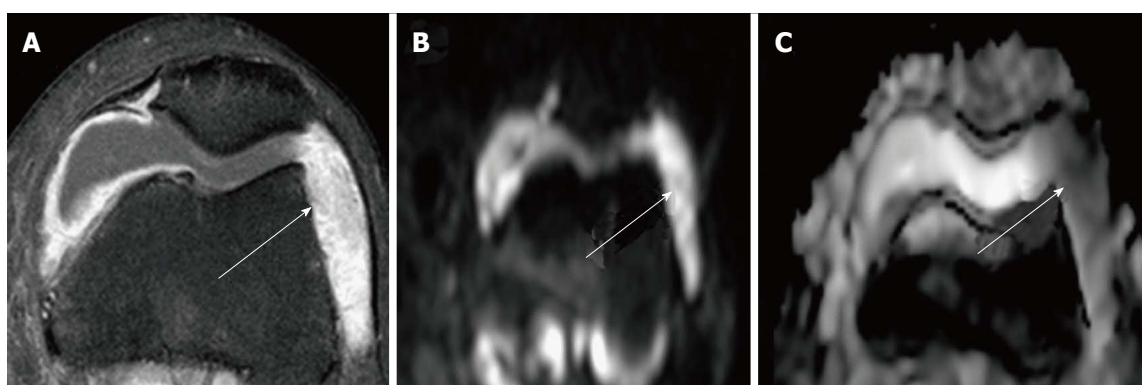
Septic synovitis. Magnetic resonance imaging findings in a 22-year-old man with knee pain and fever. A: Axial post contrast fat-suppressed TSE T1-weighted image shows a large joint effusion with synovial thickening and intense enhancement; B, C: DWI with a b value of 800 s/mm² and corresponding ADC map demonstrate areas of severely restricted diffusion (ADC: $1,8 \times 10^{-3}$ mm²/s) within the articular fluid at the lateral patellar recess consistent with exudate, as proven by arthrocentesis. DWI: Diffusion-weighted imaging; ADC: Apparent diffusion coefficient; TSE: Turbo spin echo.
